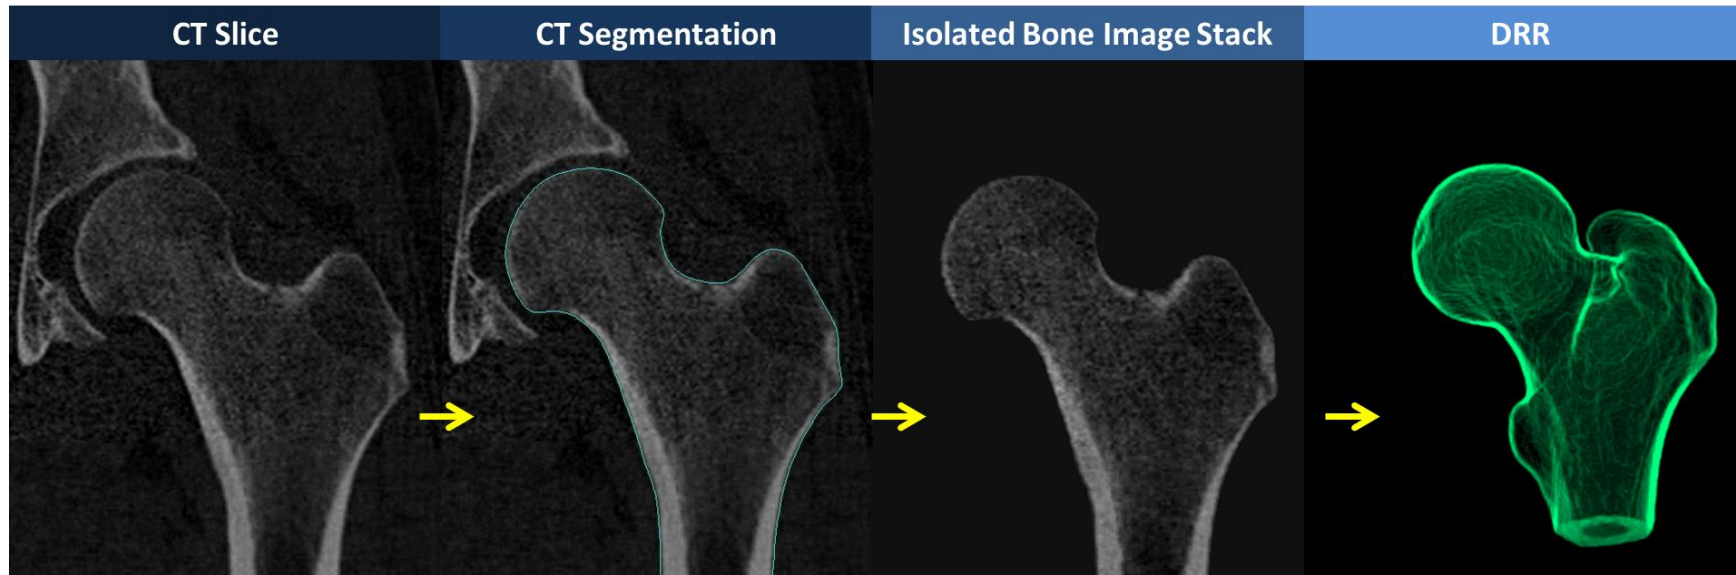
Generation of digitally reconstructed radiographs (DRRs). CT images are acquired of the joint of interest. Each bone is segmented semi-automatically. A Boolean operation applied the CT data set and segmented image labels generates an image stack containing the pixels of a single bone. Ray trace projection through this isolated image stack generates a digitally reconstructed radiograph of the bone of interest.
